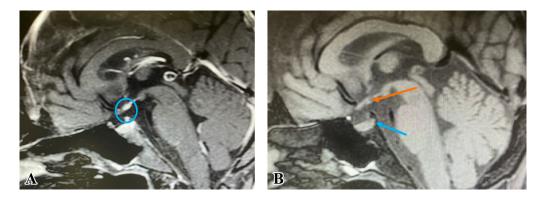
The findings of post-traumatic pituitary stalk transection syndrome in MRI.
